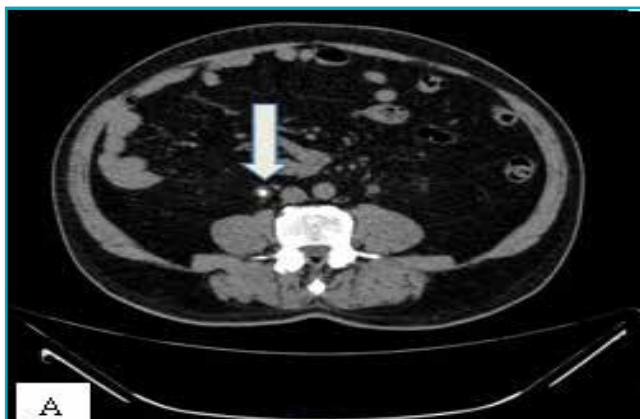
A. Axial computed tomography of kidney, ureters, and bladder (CT KUB) image showing a 6 × 4 mm calculus in the right upper ureter (white arrow), which was seen at the level of the upper border of L4, B. Axial CT KUB image showing an 8.6 × 6.6 mm calculus (1000 HU) in the left lower ureter just proximal to the ureterovesical junction (white arrow).
